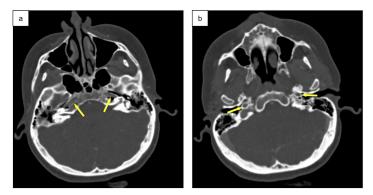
Axial non-contrast CT, using multiplanar reformation to correct for head tilt, demonstrating (a) bilateral narrowing of the petrous portions of the carotid canals (yellow arrows), with the right measuring 2.8 mm in width and the left measuring 3.1 mm; and (b) bilaterally reduced caliber of the external openings of the carotid canals (yellow arrows), both averaging 4.0 mm in diameter.
